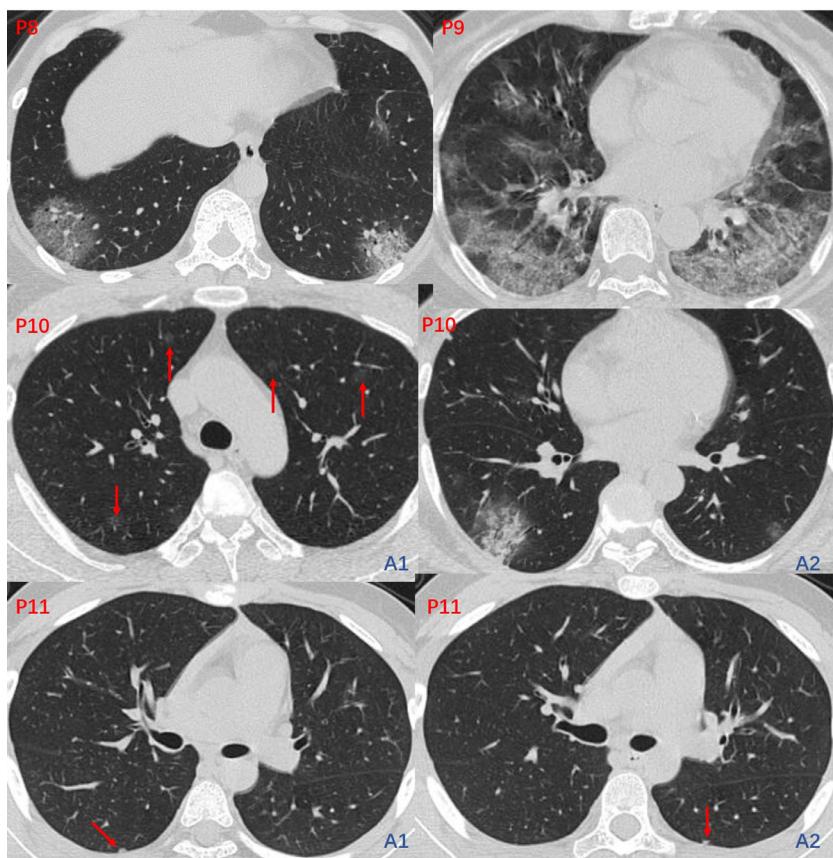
The initial CT images of P8-P11. CT images of P8 (Fig. 3, P8) and P9 (Fig. 3, P9) showed bilateral subpleural lesions with crazy paving sign. CT images of P10 (Fig. 3, P10, A1-A2) showed bilateral multiple lesions, some of them were pure GGO located in the central region of the lung. CT images of P11 (Fig. 3, P11, A1-A2) showed bilateral subpleural small nodular-like lesions.
